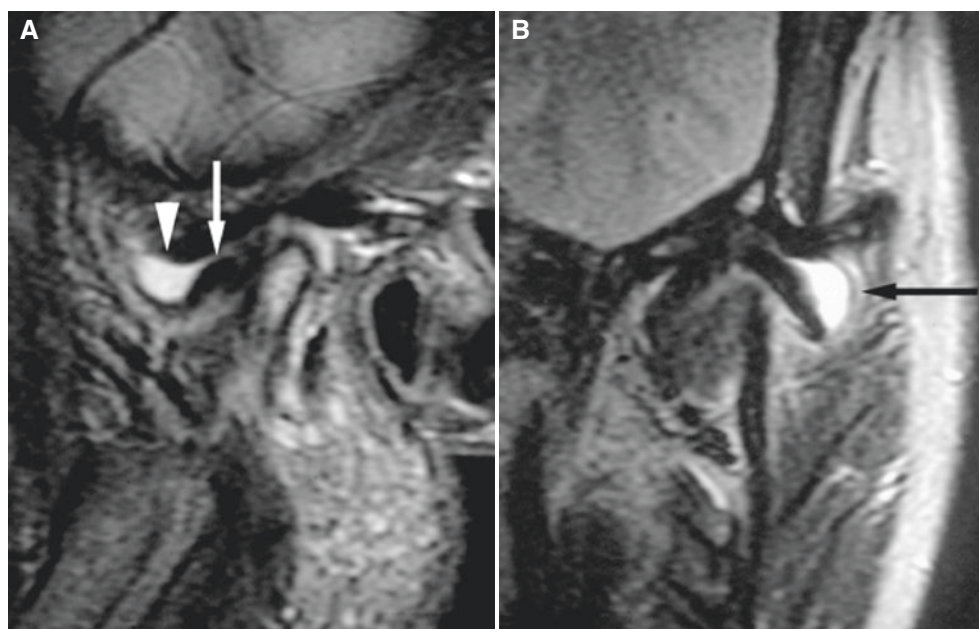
Osteoarthritis and anterolateral disc displacement, with joint effusion. Same patient as in Fig. 6.21. (A) Oblique sagittal T2-weighted MRI shows anteriorly displaced disc (*arrow*), flattened condyle, and joint effusion (*arrowhead*) in anterior recess of the upper compartment. (B) Oblique coronal T2-weighted MRI shows joint effusion in lateral part of the joint above laterally displaced disc (*arrow*)
